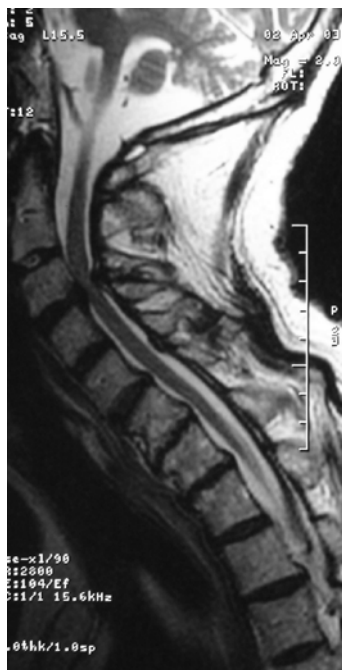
MRI of the spinal cord
